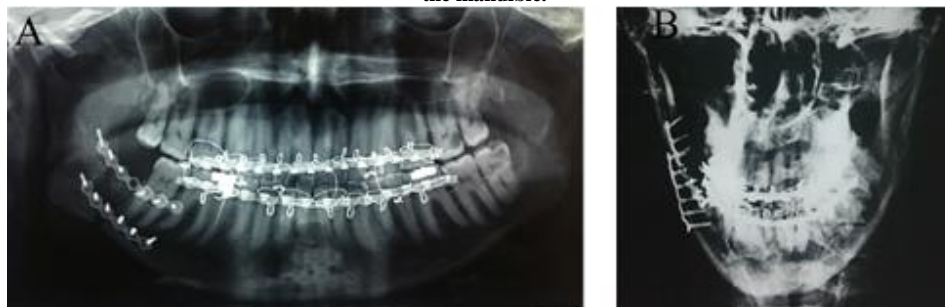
Radiographic images of the patient's mandible after open reduction and internal fixation. A- Panoramic view. B- Poster anterior (PA) view of the mandible
